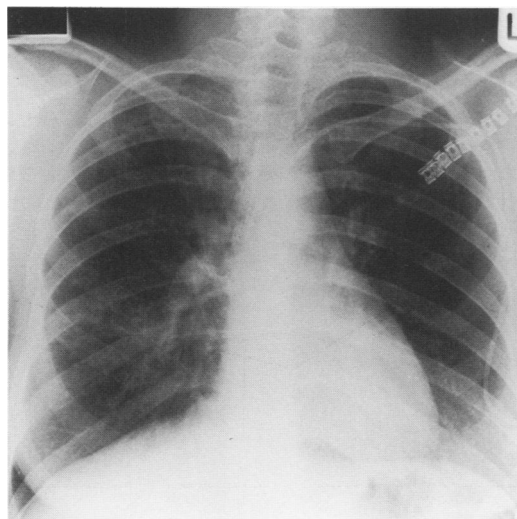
Chest radiograph from case no. 1 showing Port-a-cath tip in superior vena cava immediately after insertion.
